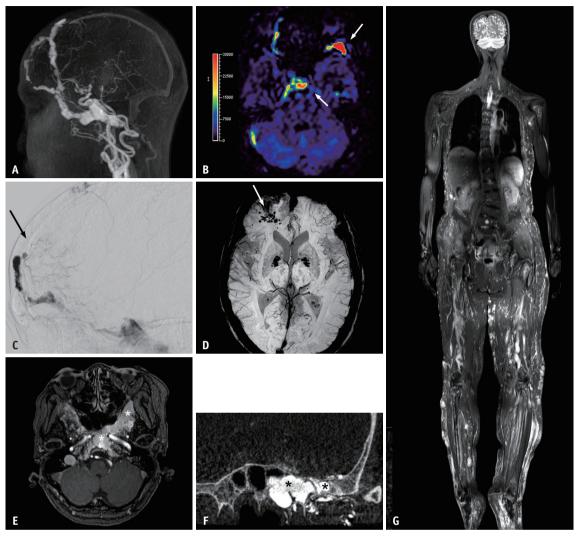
A patient diagnosed with Klippel-Trénaunay syndrome by advanced MR imaging and genetic test (*PIK3CA* positive).
